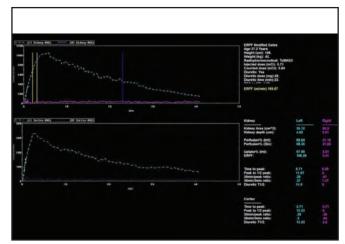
Summary of renal scintigraphy with renogram showed a non-functioning of the right kidney with severely reduced perfusion and function.
